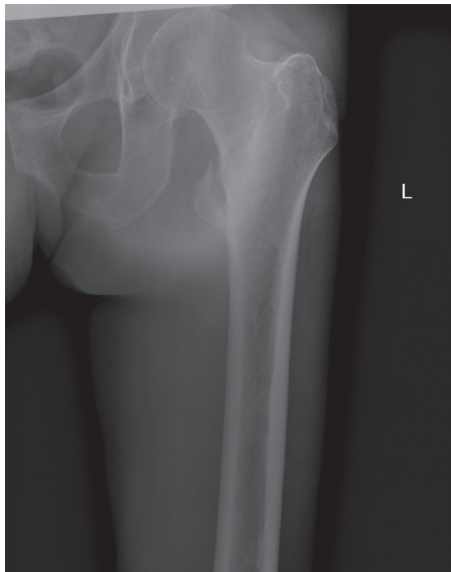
Anteroposterior radiograph of the left thigh shows an intertrochanteric femur fracture with lesser tubercle avulsion
